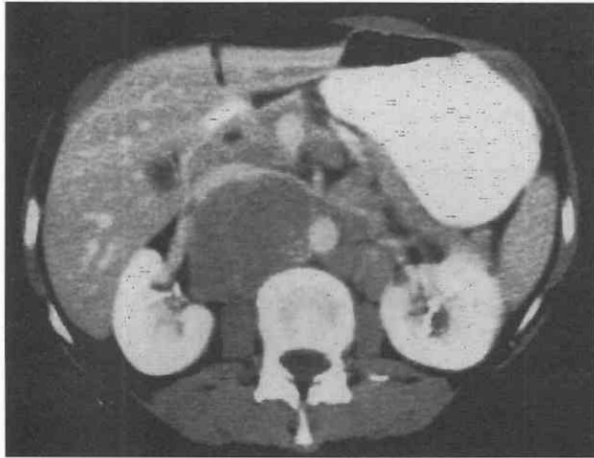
Non-Hodgkin lymphoma. Dynamically enhanced CT scan shows large lymph node masses in the para-aortic lymph node chains. The inferior vena cava is displaced anteriorly.
